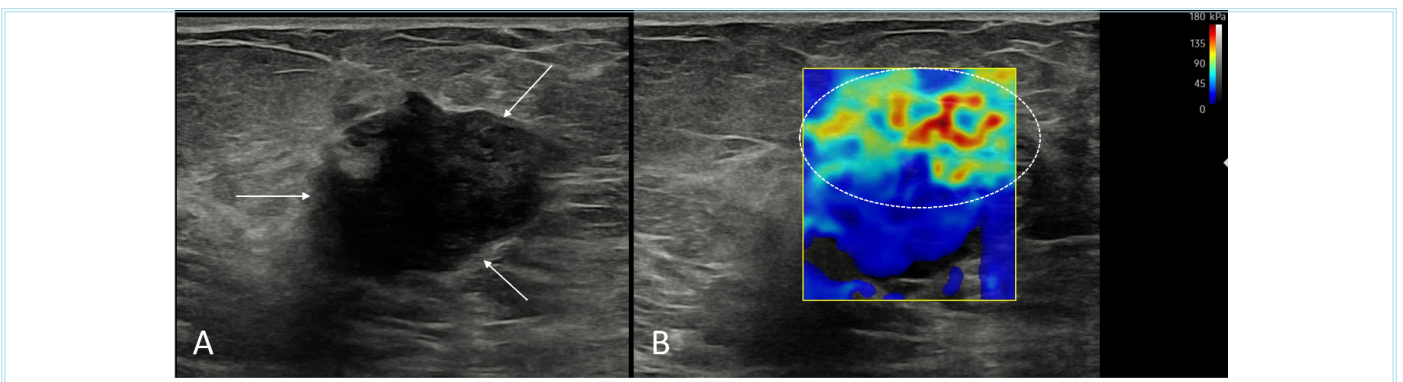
A 54-year-old female patient diagnosed with breast cancer and axillary metastasis. A) In the B-Mode ultrasound image of the left axillary pathological lymphadenopathy (arrows), findings include diffuse thickening of the cortex, absence of the fatty hilum, and a long-axis to short-axis ratio greater than two. B) In the shear wave elastography image of the same pathological lymph node, color coding indicative of tissue stiffening is observed (circle). Elastographic measurement values are not numerically presented in this figure
